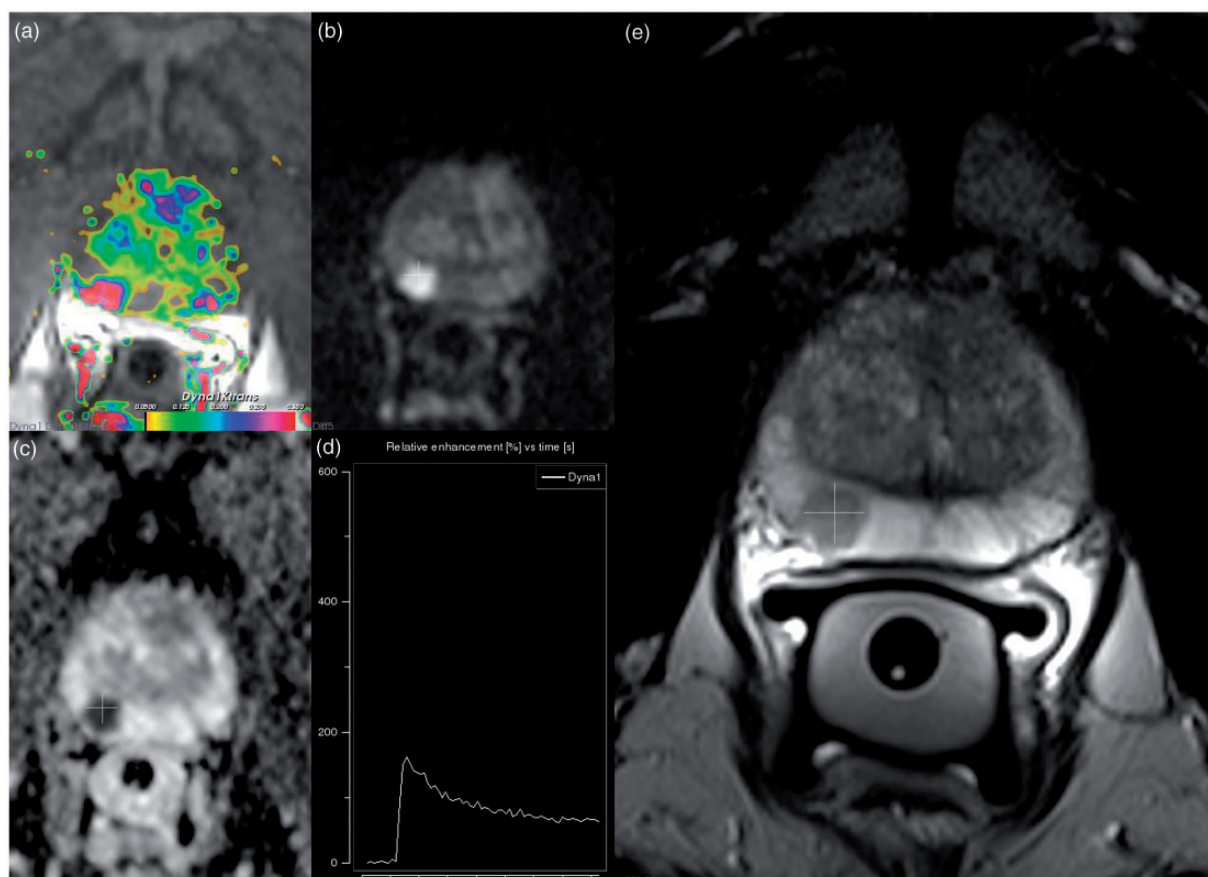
Multiparametric MRI (mpMRI) of a typical index tumor that was correctly localized. (a) DCE Ktrans parametric map: focal and asymmetric enhancement of a tumor in the right side of the peripheral zone. (b) DWI with b value 800: the tumor shows a high signal in the right side of the peripheral zone. (c) ADC map: the tumor shows low values in the right side of the peripheral zone. (d) Perfusion curve: the tumor shows a typical type-3 curve, fast enhancement, and wash-out. (e) T2W images: the tumor is sharply defined with low signal intensity in the right side of the peripheral zone.
